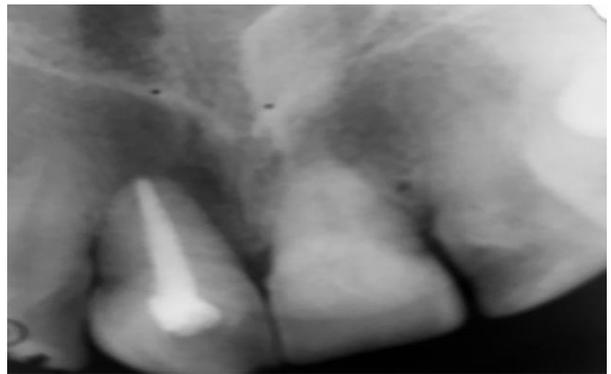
a & b: Radiographic evaluation-Pre-operative 6 months post-operative
